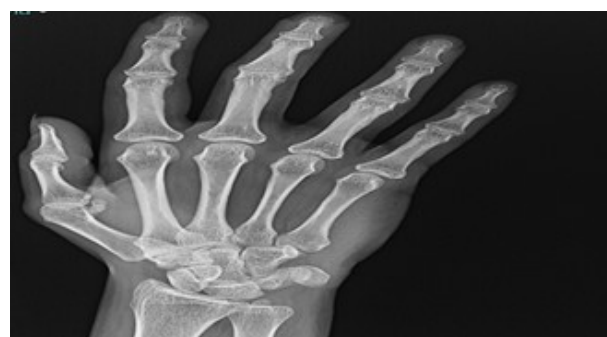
Anterior-Posterior hand radiograph of skeletally mature patient demonstrates sesamoid bones seen at the 1st and 2nd MCP joints
